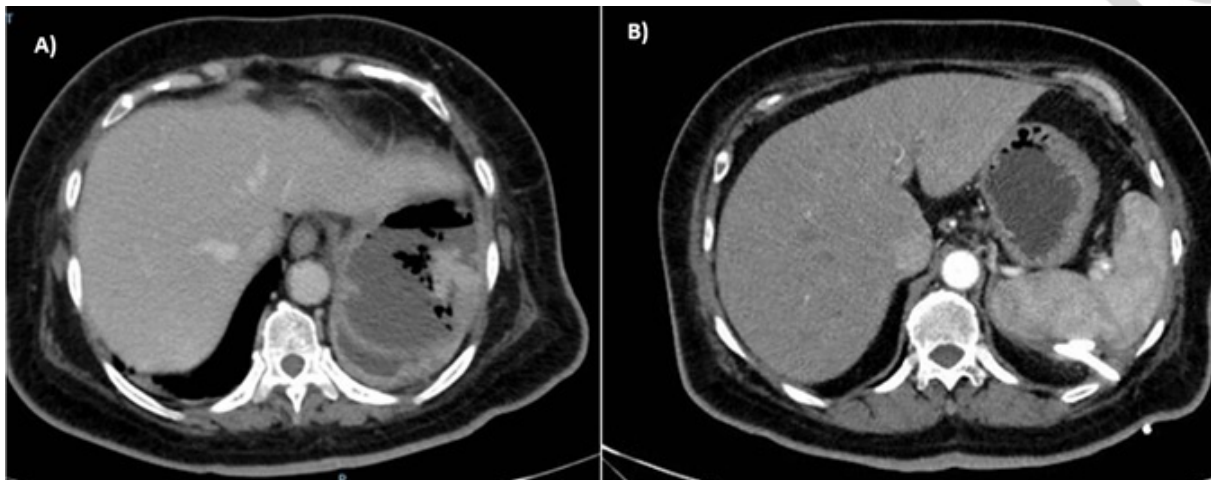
A. Abdominal CT with splenic abscess of 9.9 x 6.1 x 6.5 cm. B. Follow-up abdominal CT one month after percutaneous drainage.
